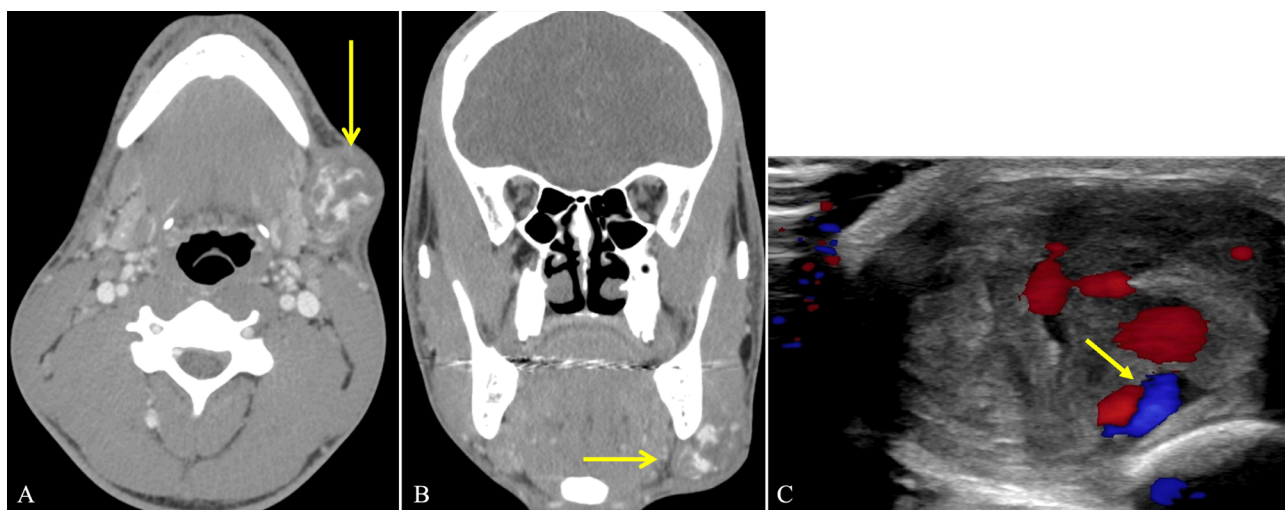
Computed tomography angiography of axial (A) and coronal (B) views of the 3-cm pseudoaneurysm (yellow arrow) located at the left mandibular angle and a color Doppler ultrasound (C) of the mass demonstrating “yin-yang” pattern (yellow arrow) consistent with a partially thrombosed pseudoaneurysm.
